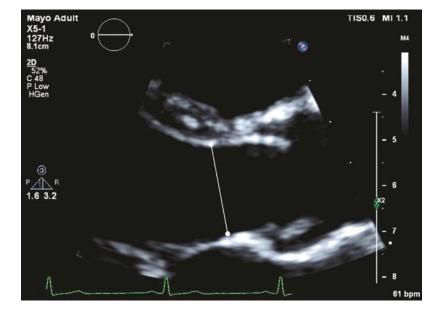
Shown is the parasternal long-axis view of the aortic root and proximal ascending aorta; measurement of the sinus of Valvsava (A), the sinotubular junction (B), and proximal ascending aorta (C) are designated to be "leading edge to leading edge"
